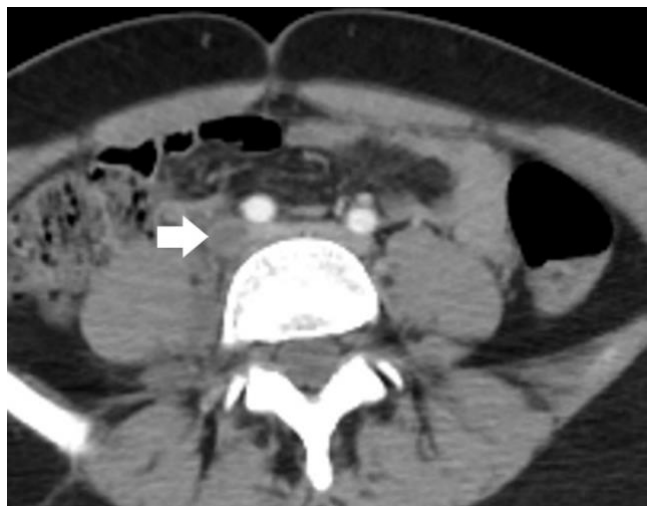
Abdominal CT; Thrombus in The Right Iliac Vein
